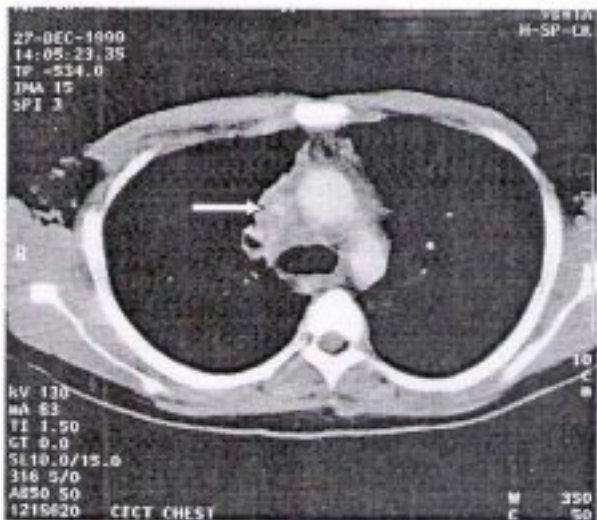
CT scan of the chest showing a conglomerate mass in the anterior mediastinum encasing and compressing the superior vena cava (arrow).
